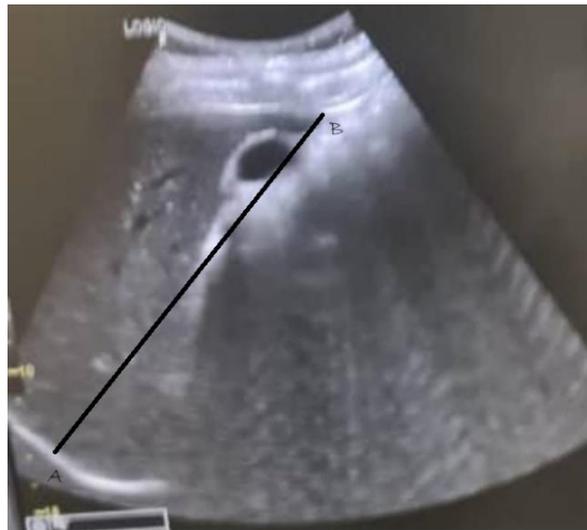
Sonographic measurement of the liver length (A-B)
